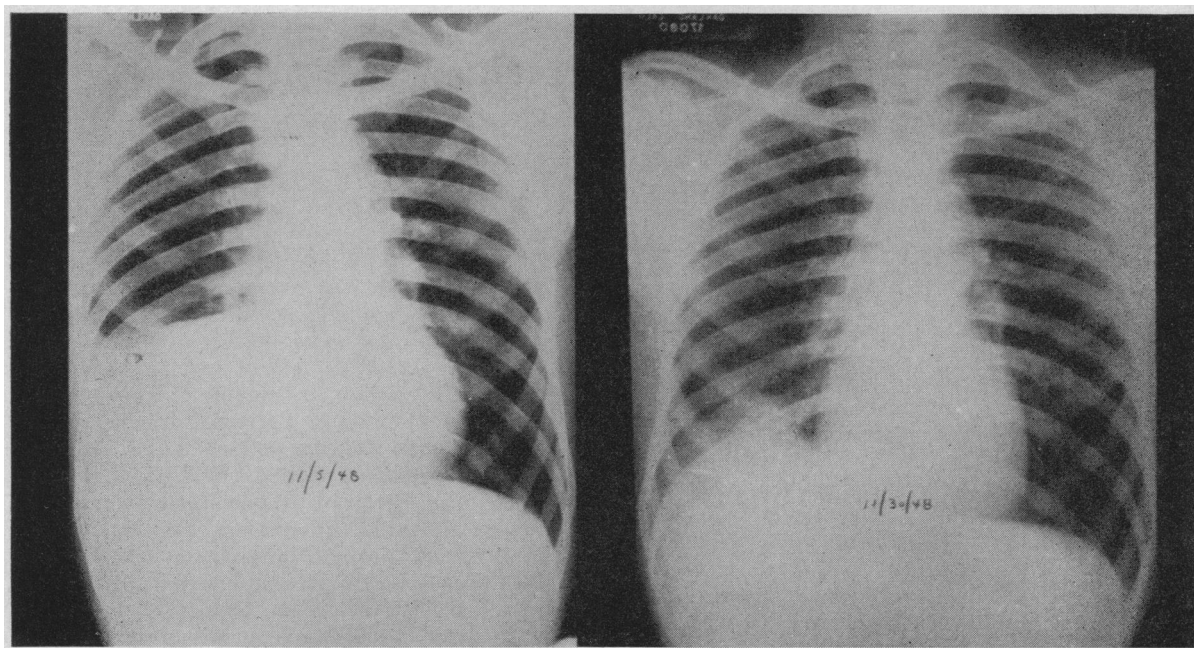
Left*—Roentgenogram before therapy in which it was noted that right diaphragm was elevated and splinted, with some reaction at the base of the right lung. *Right*—25 days later: considerable improvement but not complete return to normal.
